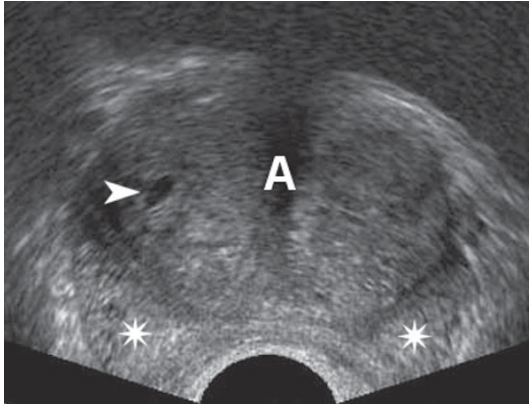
Ultrasonography. Transrectal approach. Prostatic hyperplasia. The adenoma (A) displays a nodular appearance with heterogeneous structure. A hypochoic ring separates it from the peripheral zone (*asterisks*). The *arrowhead* indicates a small retention cyst
